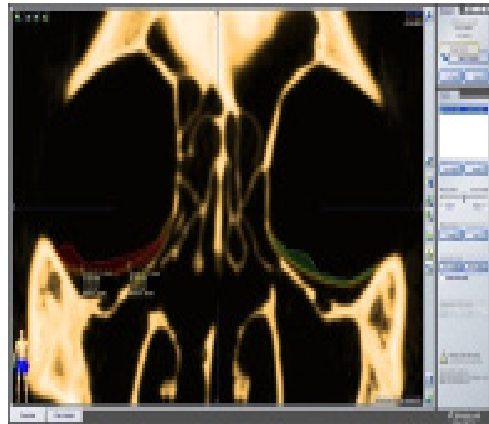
Coronal view of fused CT scan images of realized (in yellow) and planned (in red and green) implant position at the medial and lateral position of the orbital floor at the level of the inferior orbital foramen
